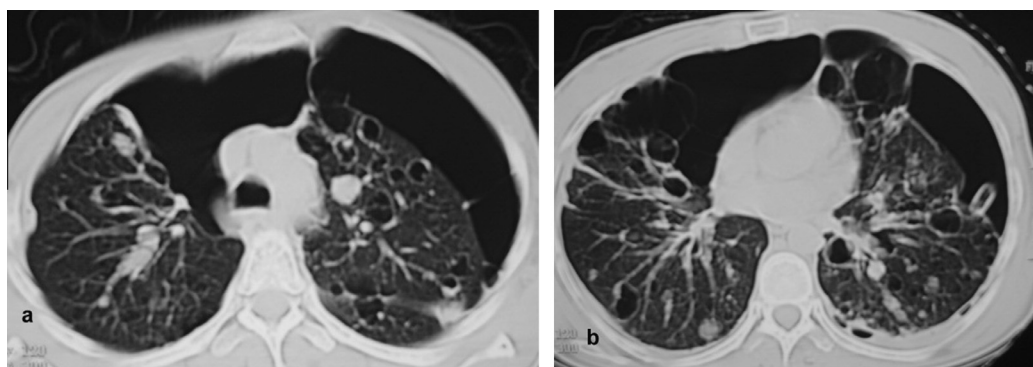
a and b: 25-year-old female patient with LAM presenting recently with chest pain, progressive dyspnea and dry cough. HRCT axial images showing bilateral air-filled, opaque (fluid-filled) cysts and partially loculated pneumothorax on both sides. An intercostal tube is noted on the left side.
